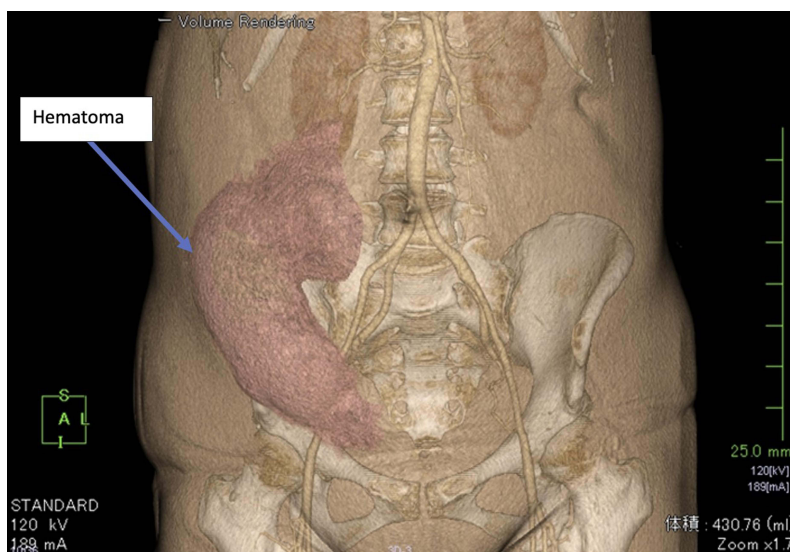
3D-CT 4 of the hematoma 4 hours after onset. The subcutaneous hematoma is clearly visualized.
